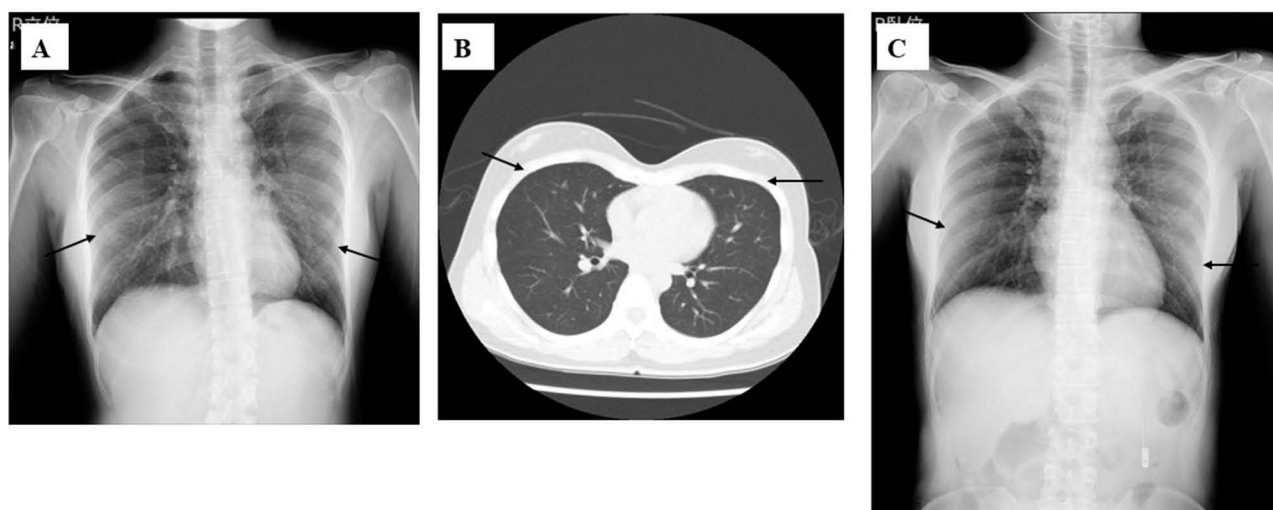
Chest X-rays (A and C) and computed tomography (B) of the Case 3 patient. At admission, there are abnormal shadows on the chest X-ray (A) and computed tomography (B), but these shadows improve after treatment (C). Arrows indicate the abnormal shadows.
